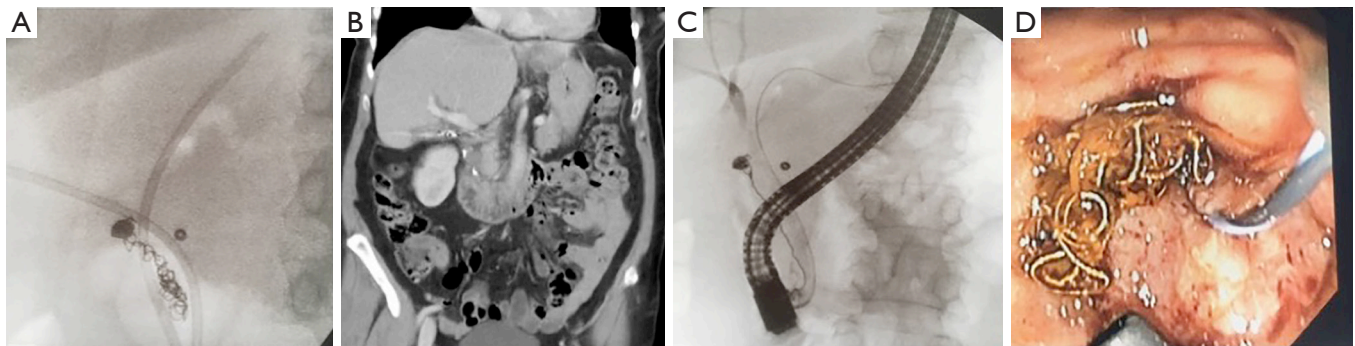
Radiography and CT scan showing migrated vascular coils into the common bile duct before biliary stent removal (A,B). Cholangiogram and endoscopy showing migrated vascular coils into the common bile duct after biliary stent removal (C,D).
